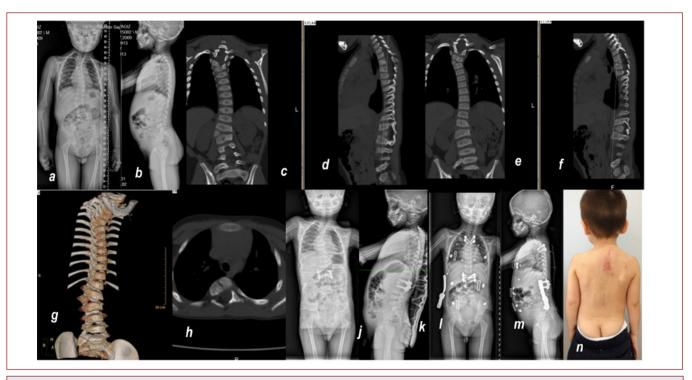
Patient Y.A., a 4-year-old male, had upper thoracic and thoracolumbar hemivertebrae. Both hemivertebrae were resected in two different sessions by a posterior approach. a) Standing PA X-ray of the patient, b) lateral X-ray, c,d,e,f) computerized tomography images, g) 3D tomography images, h) axial MRI, j.k) postoperative PA and lateral X-rays, l,m) last follow-up AP and lateral X-rays, n) posterior image of the patient at the last follow-up.
